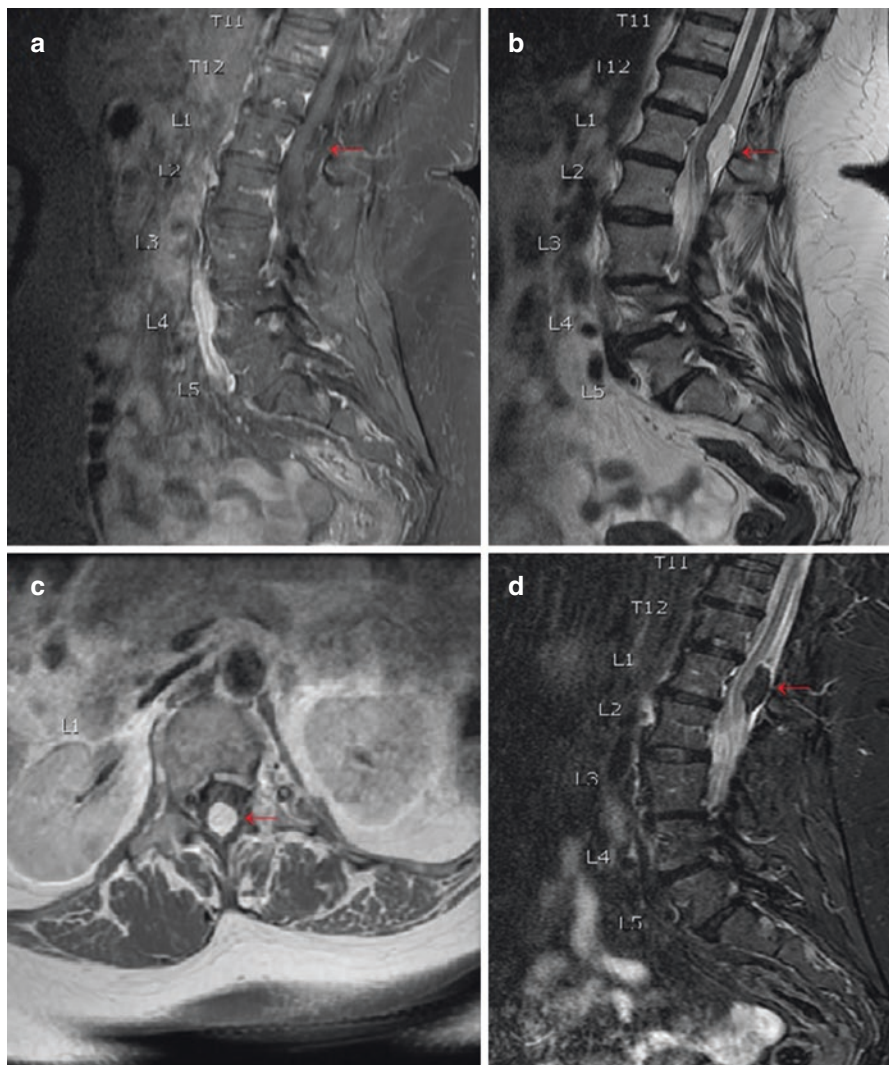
Lumbar spine MRI showing tethered spinal cord with conus medullaris at the L2 level. Imaging also shows a 28 mm × 11 mm × 10 mm fat signal mass at T12–L1 level compressing the posterior aspect of distal spinal cord. (a) Midline sagittal view of T1-weighted with contrast. (b) Midline sagittal view of T2-weighted. (c) Axial view of T1-weighted with contrast at L1 vertebral body level. (d) Midline sagittal view of STIR series
